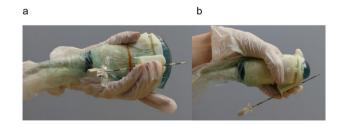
Epiguide mounted on ultrasound probe with epidural needle in situ (a) probe orientated in sagittal plane, (b) probe orientated in transverse plane
